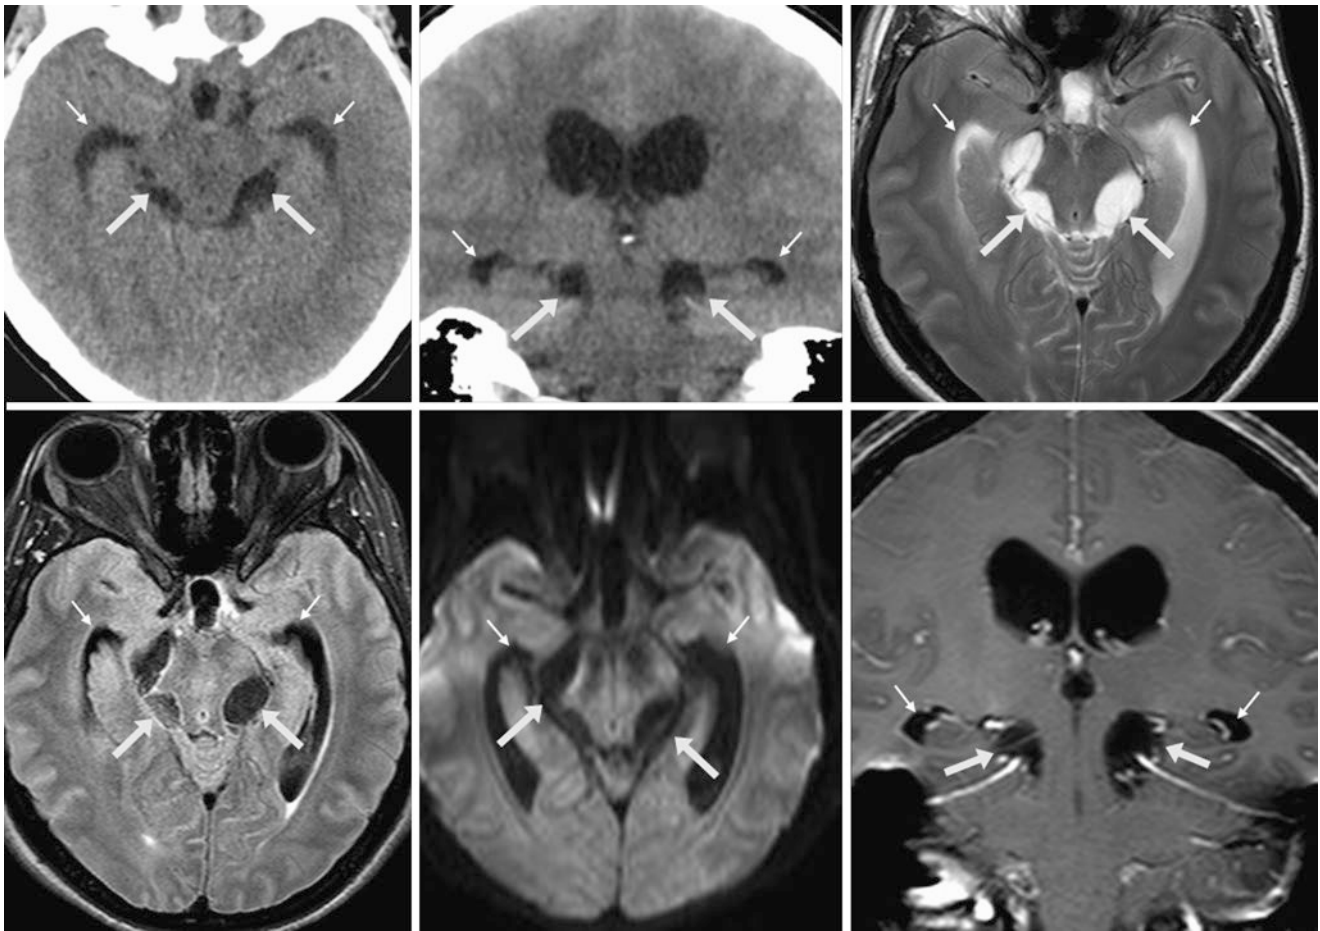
Comparison case of racemose neurocysticercosis. On axial (*top left*) and coronal (*top middle*) NECT, a 33 year old had cystic enlargement of the perimesencephalic cisterns (*arrows*) and mild enlargement of the temporal horns (*tiny arrows*). Axial T2WI (*top right*), FLAIR (*bottom left*), DWI (*bottom middle*), and postcontrast
